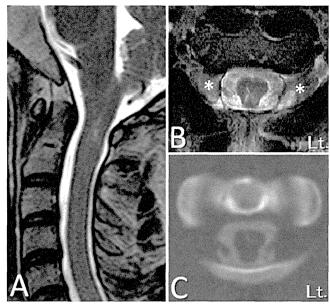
Case 2. A: Sagittal T2-weighted MR image taken in the neutral position showing spinal cord swelling with a higher signal intensity region at C1–2. B: Axial T2-weighted MR image at C1–2 demonstrating tumors at the bilateral lateral portion of the C1–2 interlaminar space (asterisks). B and C: Axial T2-weighted MRI and CTM scans at C1–2 revealing a trapezoidal deformity of the spinal cord despite adequate subarachnoid space around the spinal cord.
